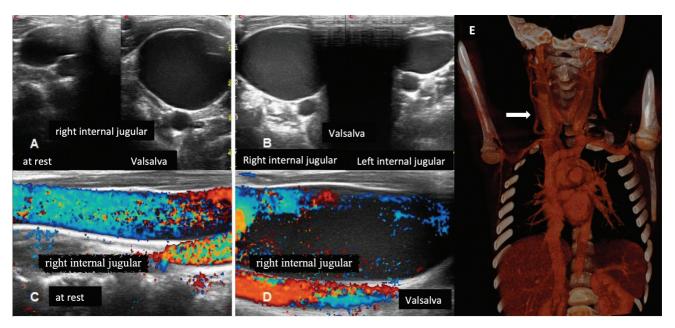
(A) Ultrasound (US) of the right internal jugular vein at rest and at Valsalva maneuver; (B) right and left internal jugular veins comparative size; (C) right internal jugular vein color Doppler US demonstrating normal venous flow without thrombosis at rest and (D) under Valsalva maneuver. (E) Computed tomography (CT) contrast scan showing right internal jugular vein ectasia (shown by the arrow).
